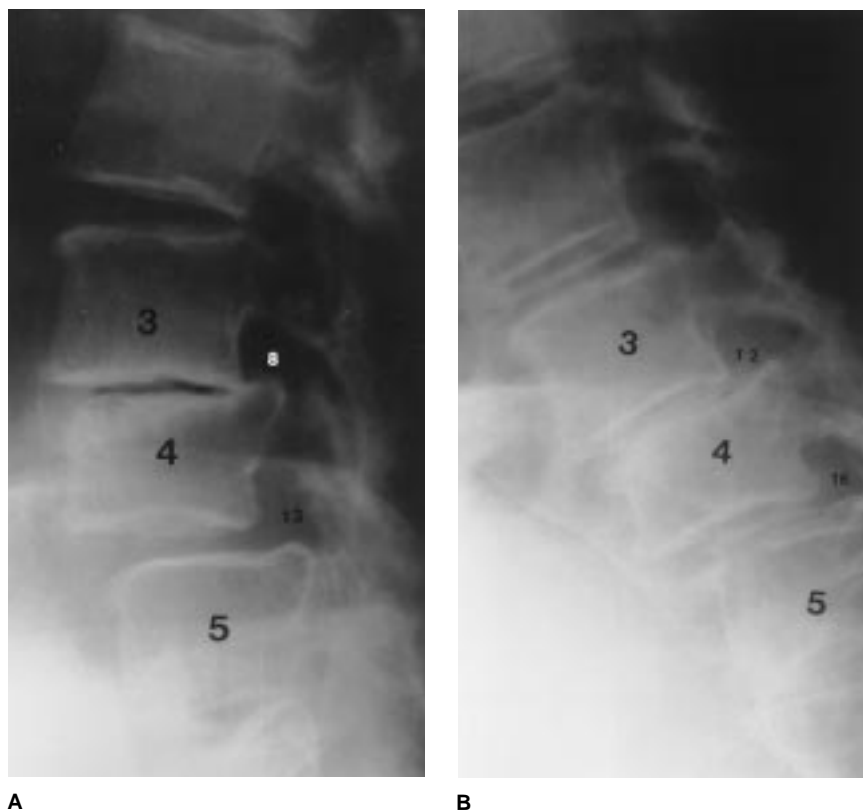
Lateral lumbar radiographs depicting dynamic instability due to spondylolisthesis at L3-4 and L4-5. A, In extension, the anterior translation measures 8 and 13 mm, respectively. B, In flexion, the anterior translation measures 12 mm and 16 mm, respectively.
